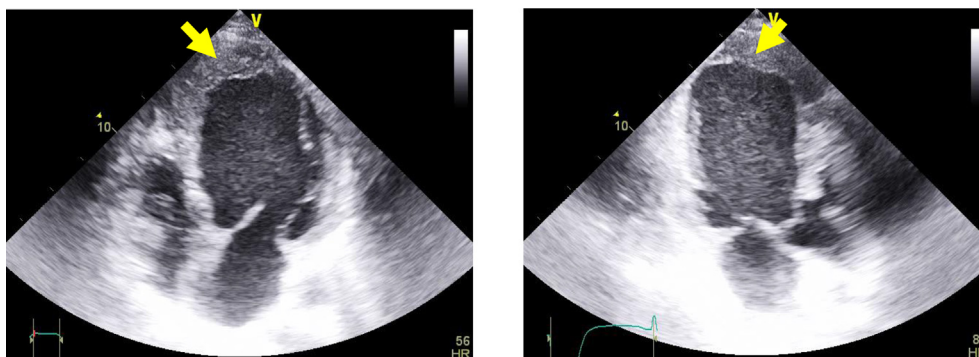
Subsequent 2D trans-thoracic echocardiography 3 months later showing Increased echogenicity over the apex (yellow arrows), consistent with thrombus formation.
